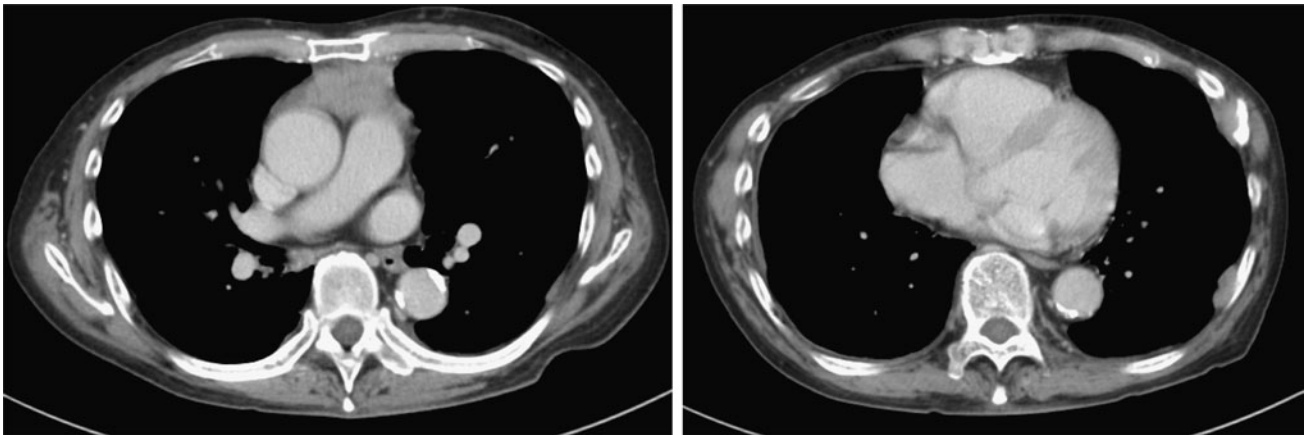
a, b Chest CT scans after four cycles of ADOC chemotherapy show a decrease in both the mediastinal mass and pleural dissemination
